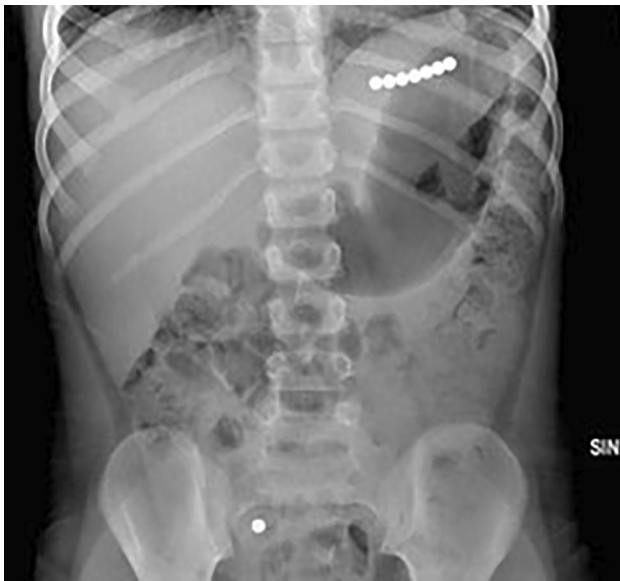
Basal abdominal X-Ray showing 7 magnets in the epigastric area and one in the right iliac fossa
